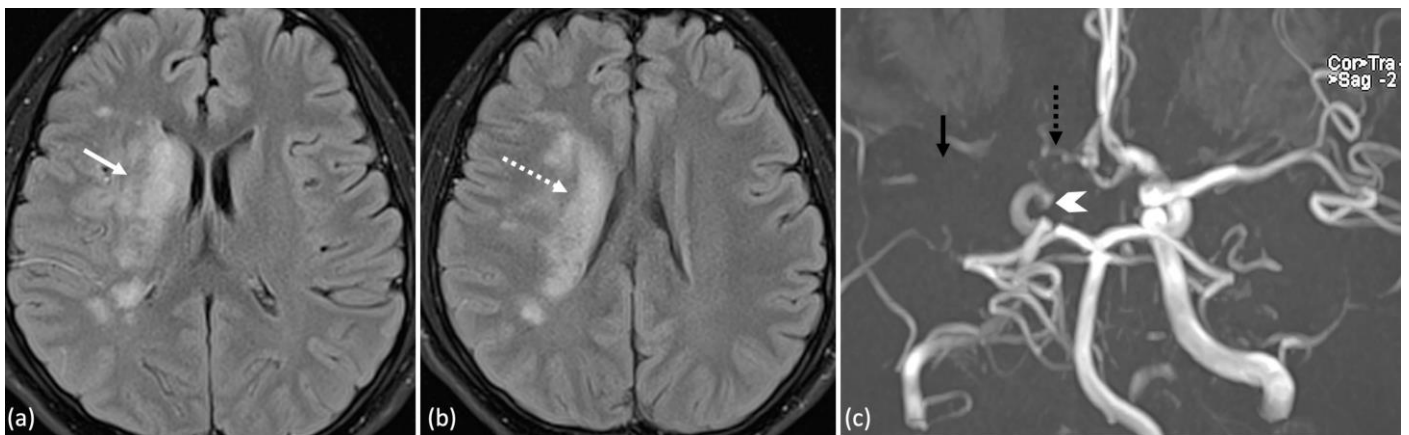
MRI and MRA images; (a) and (b) MRI Axial FLAIR sequence demonstrates acute infarct at the right basal ganglia and external capsule (white arrow) extending to the right corona radiata (dotted arrow). (c) MRA of the Circle of Willis demonstrates right intracranial stenosis at the terminal aspect of the right internal carotid artery (ICA) (white arrowhead). Note that the right middle cerebral artery (MCA) is not visualized here compared to the normal left side (black arrow), suggestive of right MCA stenosis. There is also stenosis of the A1 segment of right anterior cerebral artery (ACA) (black dotted arrow).
